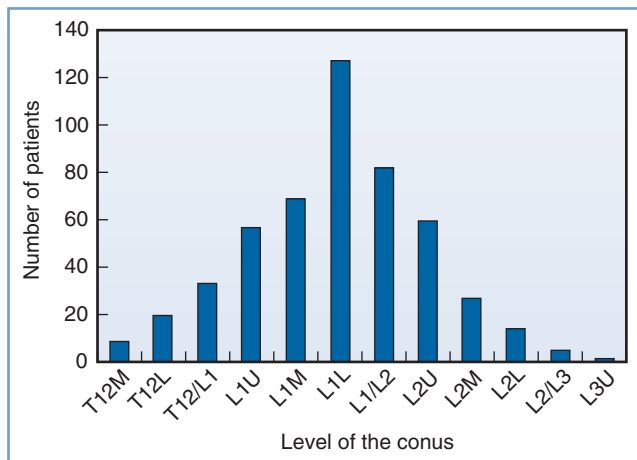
■ Variation in the level of the tip of the conus medullaris assessed by magnetic resonance imaging of the lumbar spine among 504 consecutive adults. *L*, lower third of vertebral body listed; *M*, middle third of vertebral body listed; *T12/L1*, interspace between T12 and L1; *U*, upper third of vertebral body listed. (Data derived from Saifuddin A, Burnett SJ, White J. The variation of position of the conus medullaris in an adult population: a magnetic resonance imaging study. *Spine* 1998; 23:1452-6.)
